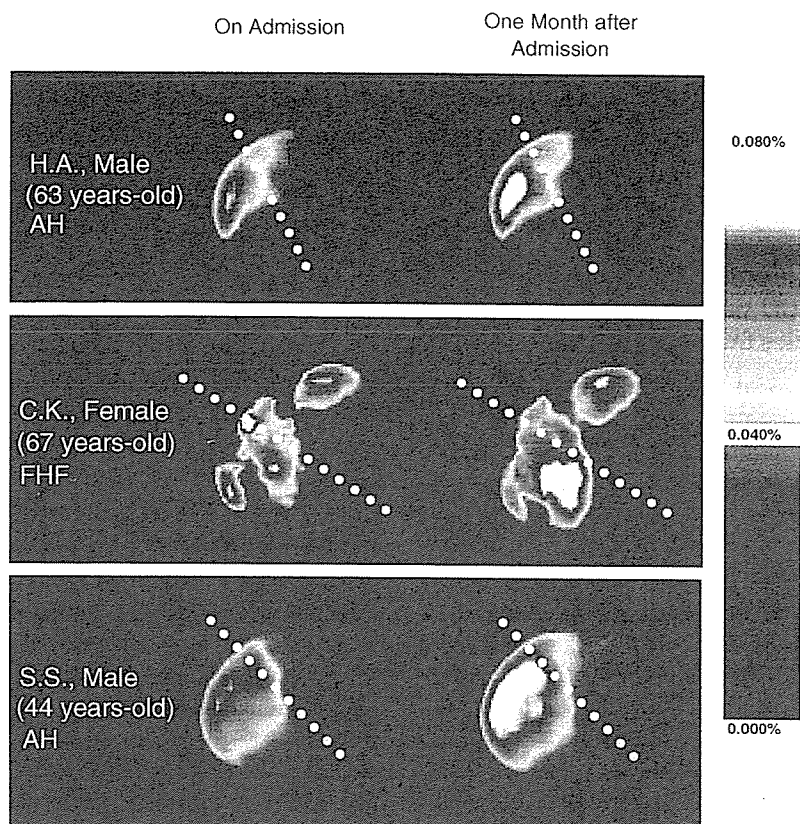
Typical liver SPECT images taken during the acute and recovery phases in patients with AH and FHF. The liver SPECT images were taken 0 and 4 weeks after admission, showing the increase in the liver uptake of ^{99m}Tc -GSA. The yellow dotted lines indicate the borderline (Cantlie's line) between the right and left hepatic lobes.
